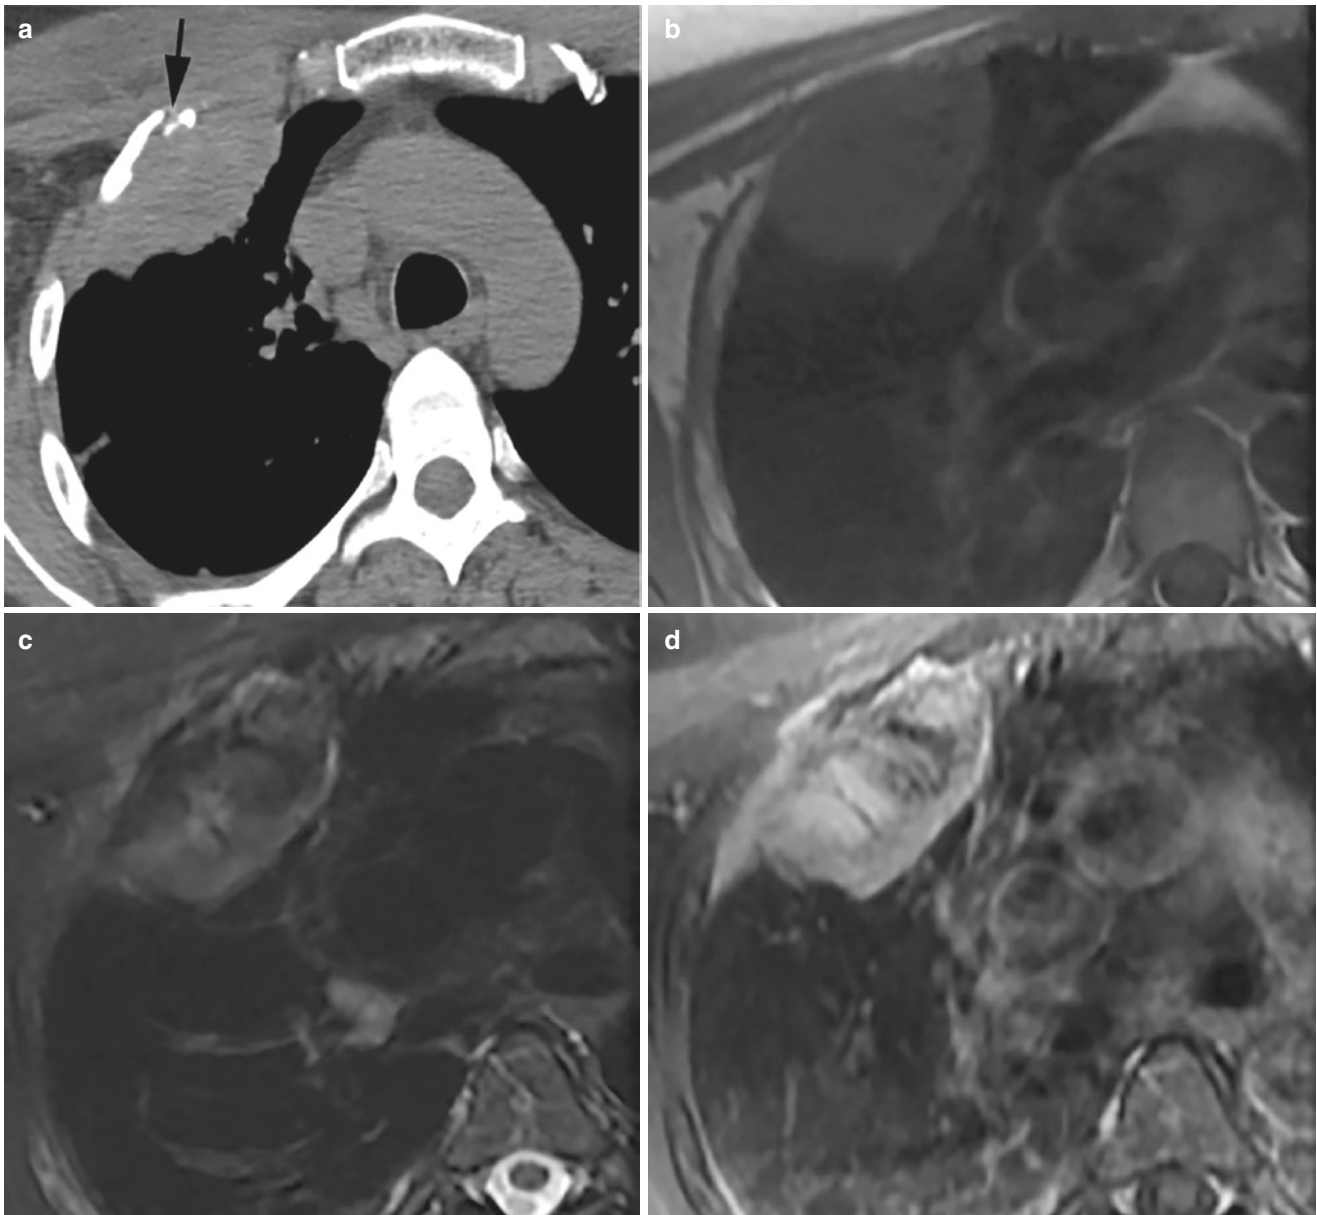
Desmoid tumor. (a) Axial CT shows peripheral soft tissue mass in the right anterior pleura with adjacent rib erosion (arrow), (b) axial T1-weighted MRI shows the mass has low signal intensity, (c)
